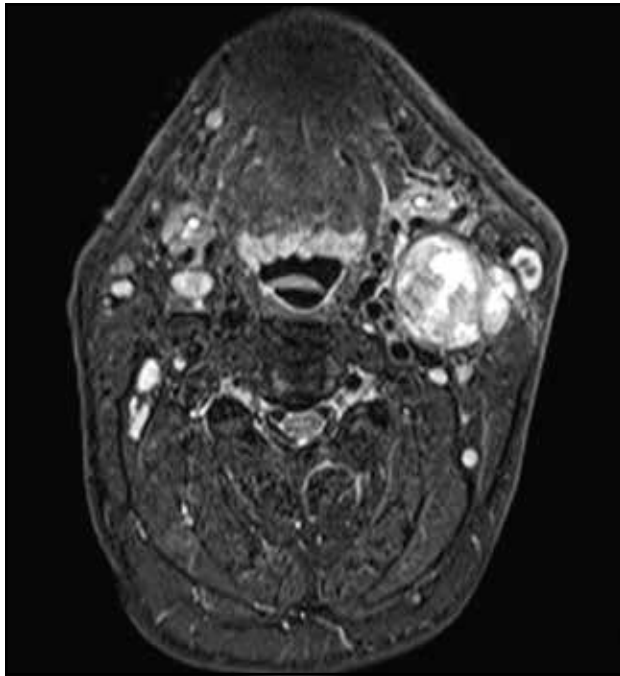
Neck MRI, axial slice –left parotid tumor with extension at vital vascular structure and facial nerve involvement.
